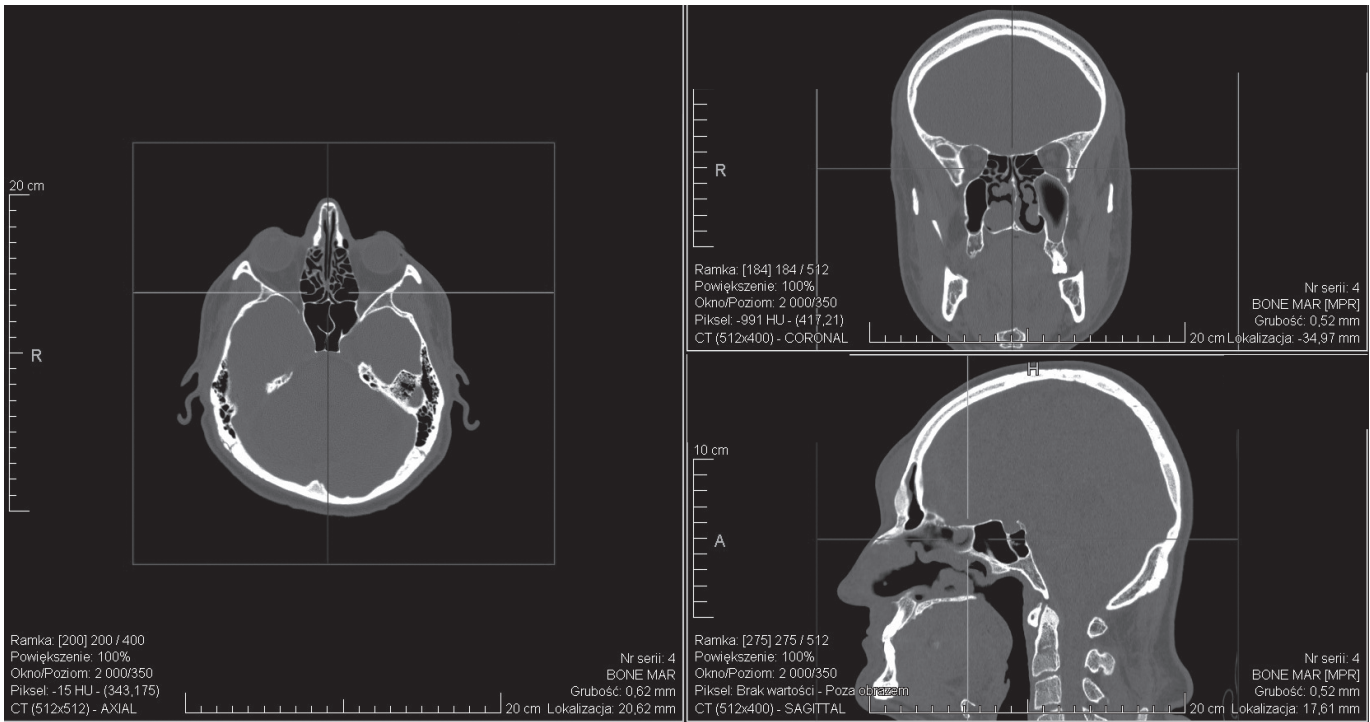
Non-contrast-enhanced CT of the paranasal sinuses on admission
